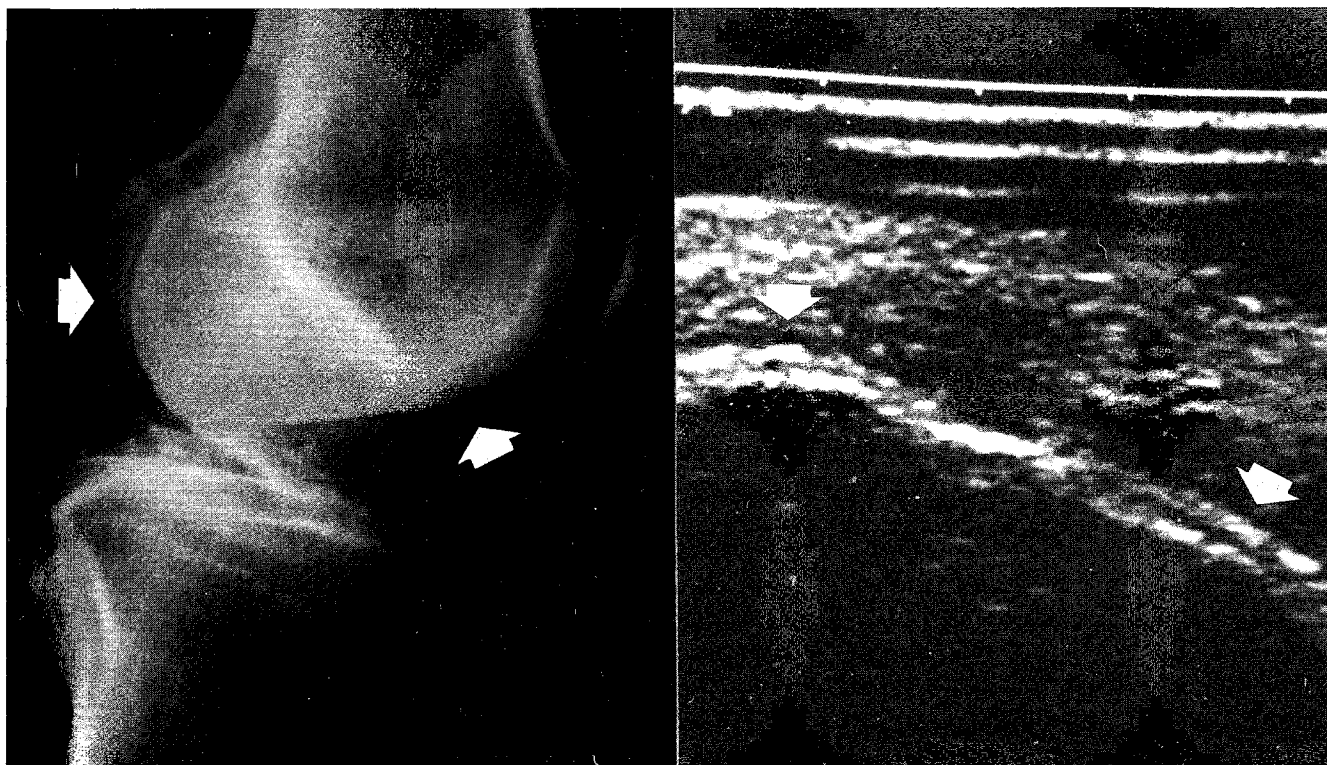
Radiographic (a) and sonographic (b) findings of cartilaginous calcifications in CC.
